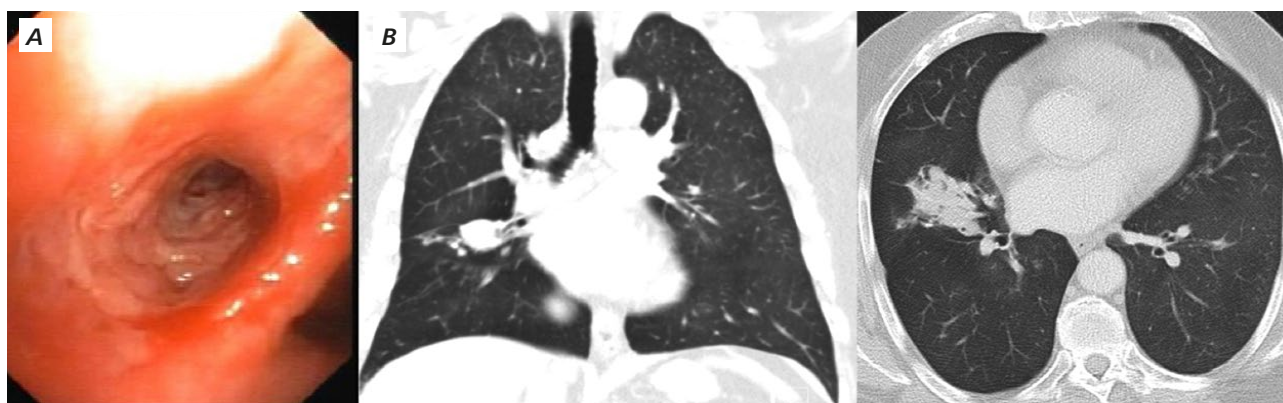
Preoperative workup with A - bronchoscopy findings showing bleeding from medium lobe bronchus, and B - CT scan showing coronal (left) and axial (right) views of the lung cavitated lesion.
